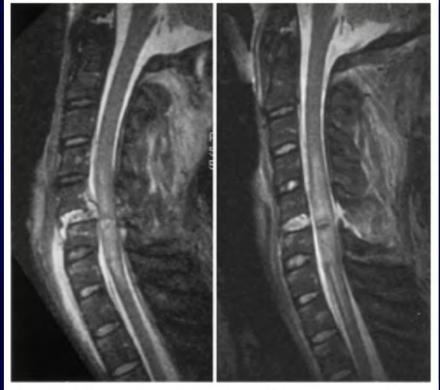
Midline sagittal MR images of the cervical spine showing *(left)* disc extrusion into the spinal canal and posterior to the C-5 body with associated spinal cord edema (TR 4705, TE 34) and *(right)* reduction of the disc herniation following closed reduction and persistent spinal cord edema extending from C4–7 (TR 6101, TE 34).
